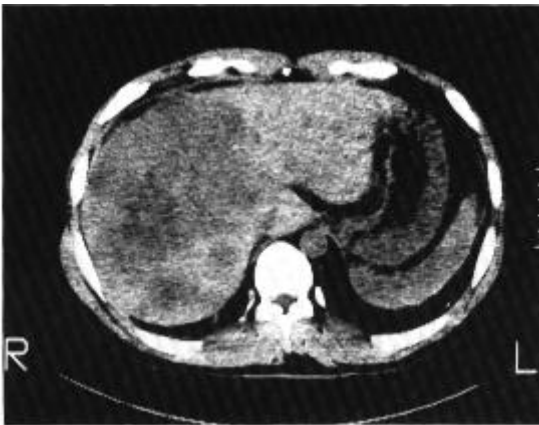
(a) X-CT of a hepatoma case. Large low density area was seen in the right lobe. (b) Sequential tomogram of this case with ^{18}FDG . In the initial image, the activity distributed uniformly in the liver. There was an increase of activity in the frontal part of the liver.
